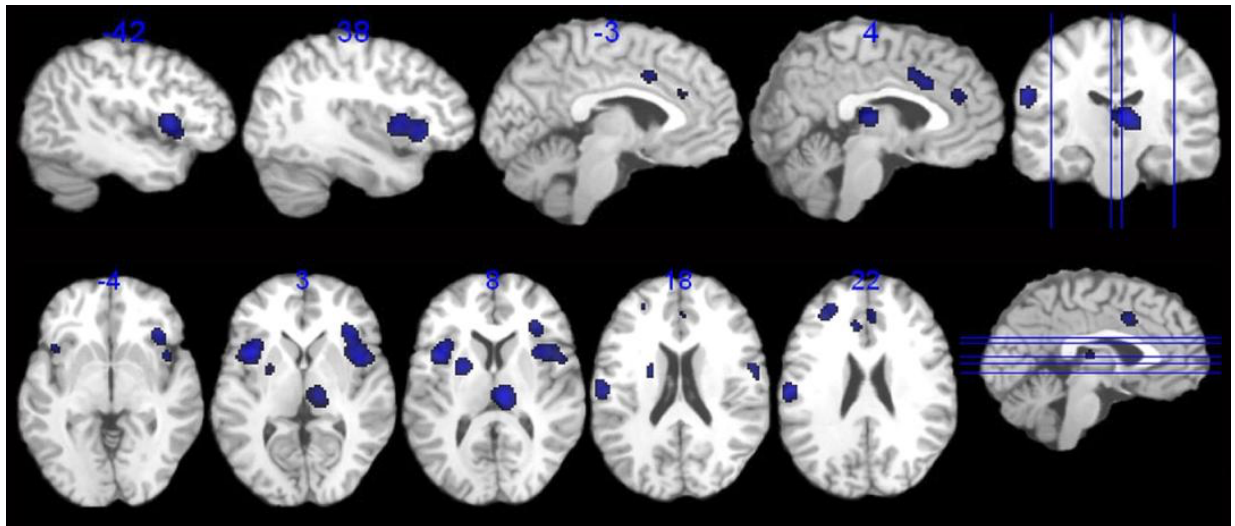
Functional MRI brain showing regions consistently activated in response to supraliminal lower gastrointestinal inflation across healthy control studies, including those associated with visceral sensation
